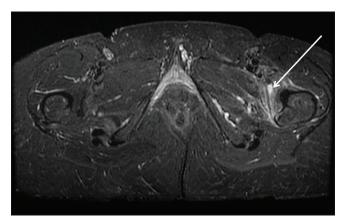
Axial short inversion time inversion-recovery magnetic resonance imaging image demonstrating inflammation and edema of the left iliopsoas myotendinous junction/bursa, at its attachment to the lesser trochanter (white arrow). Focal subtle bone marrow edema in the lesser trochanter enthesis with its surrounding increased adjacent soft tissue edema. Enthesitis and tendinopathy should warrant a raised index of suspicion for SpA.
